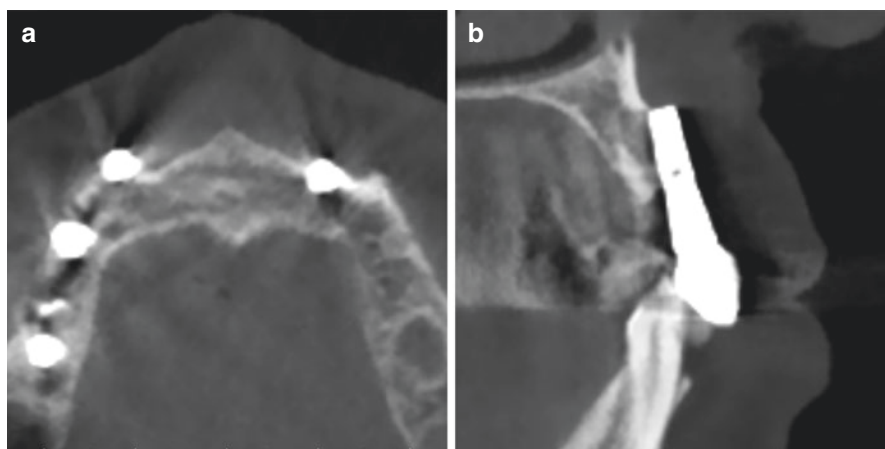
Buccally positioned implants #7 and 10 on CBCT imaging. (a) Axial view showing loss of the labial cortex adjacent to both implants. (b) Cross-sectional view of implant #7 showing marked buccal positioning and complete dehiscence of the labial cortex
